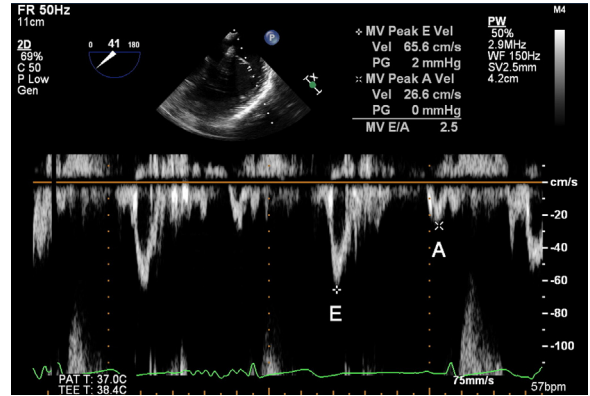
Mitral inflow demonstrating E-wave velocity and A-wave velocity in sinus rhythm with pulsed-wave Doppler from a midesophageal 4-chamber view. The mitral E-wave velocity was 65.6 cm/s and the A-wave velocity was 26.6 cm/s (E, early diastolic rapid filling velocity; A, late diastolic filling velocity).
